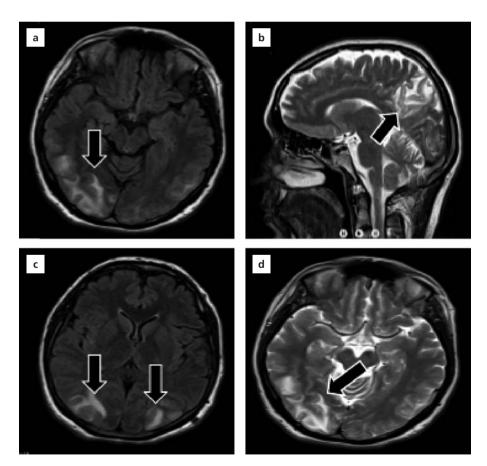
An increase is observed in the signal intensity together with cortical and sub-cortical edema in the areas shown by black arrows on FLAIR (a and c) and T2 weighted (b and d) images.
